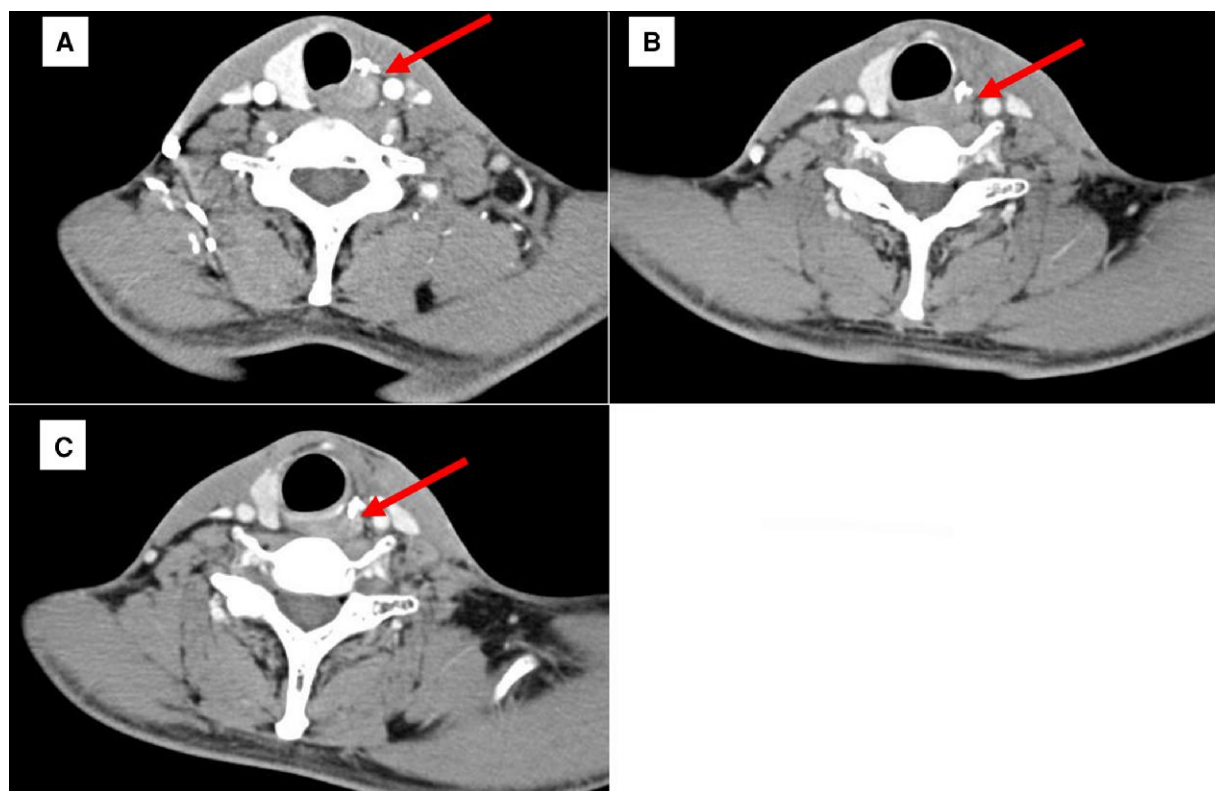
Neck computed tomography image of the recurrent tumor in the left thyroid operation bed. (A) A recurrent tumor was observed in the left thyroid operation bed 6 months after the second surgery. (B) The tumor size decreased after 2 months of sorafenib treatment. Radiofrequency ablation and external beam radiation therapy were performed before sorafenib initiation. (C) The tumor size remained stable after 11 months of sorafenib treatment.
